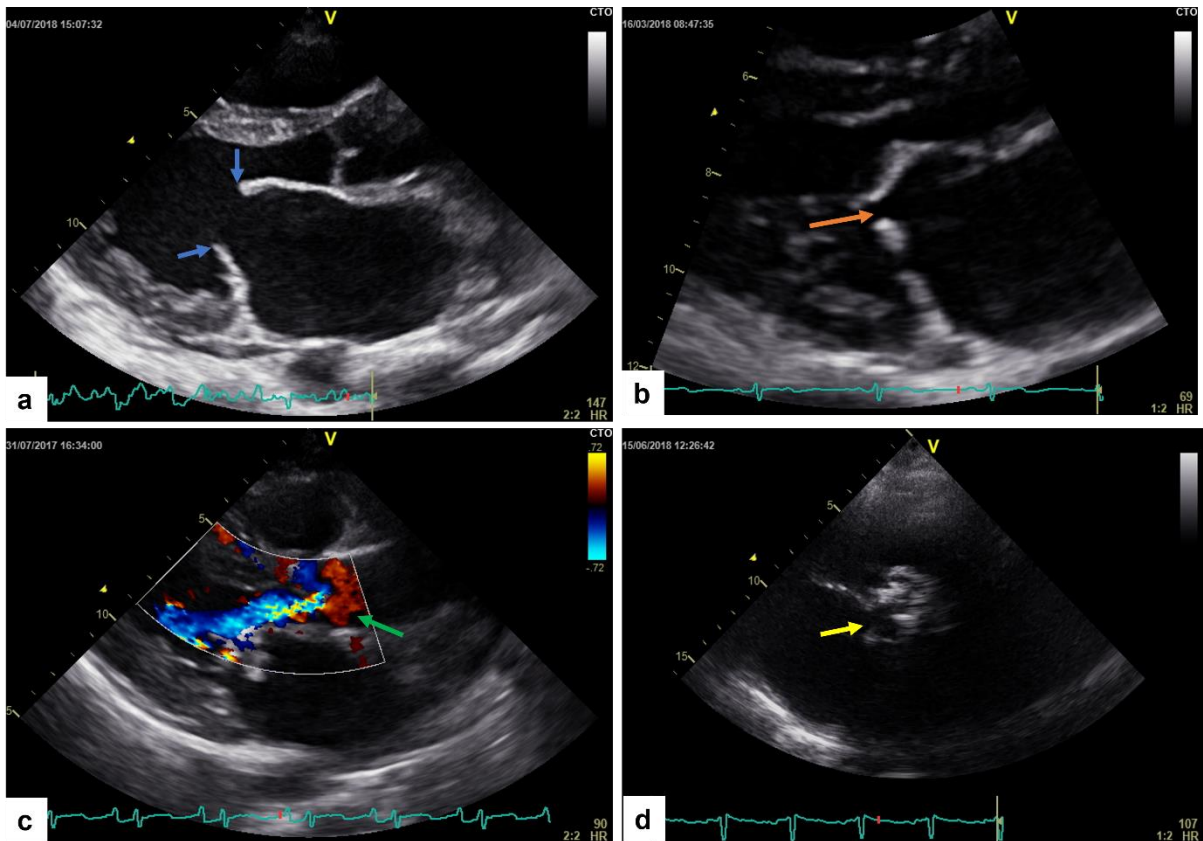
Echocardiographic images of a RHD patient with multiple valvular lesions (a) blue arrows show a regurgitant mitral valve with thickened mitral valve leaflets (b) orange arrow shows stenosed mitral with a diameter of $< 1.0\text{ cm}$. Colour Doppler echocardiographic image revealing (c) green arrow shows aortic regurgitation with Doppler beam revealing the severity of regurgitation across the valve (d) yellow arrow shows aortic stenosis (Note the narrowed and incomplete opening of the valve).
